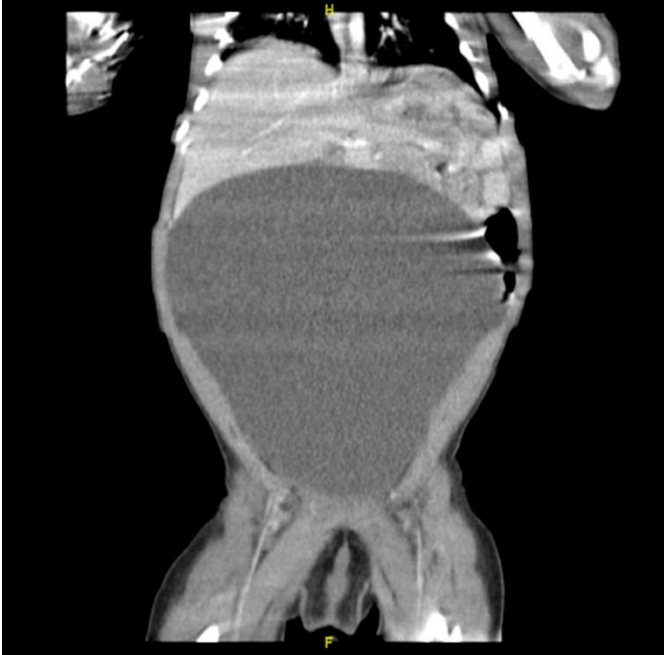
CT scan of the abdomen (Anteroposterior)
